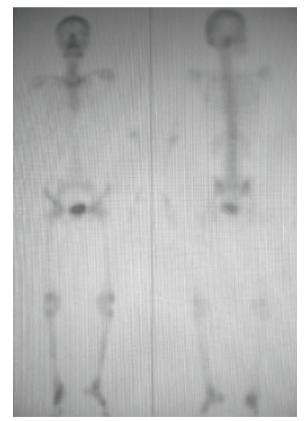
Whole-body bone scintigraphy showing no evidence of skeletal metastases.
